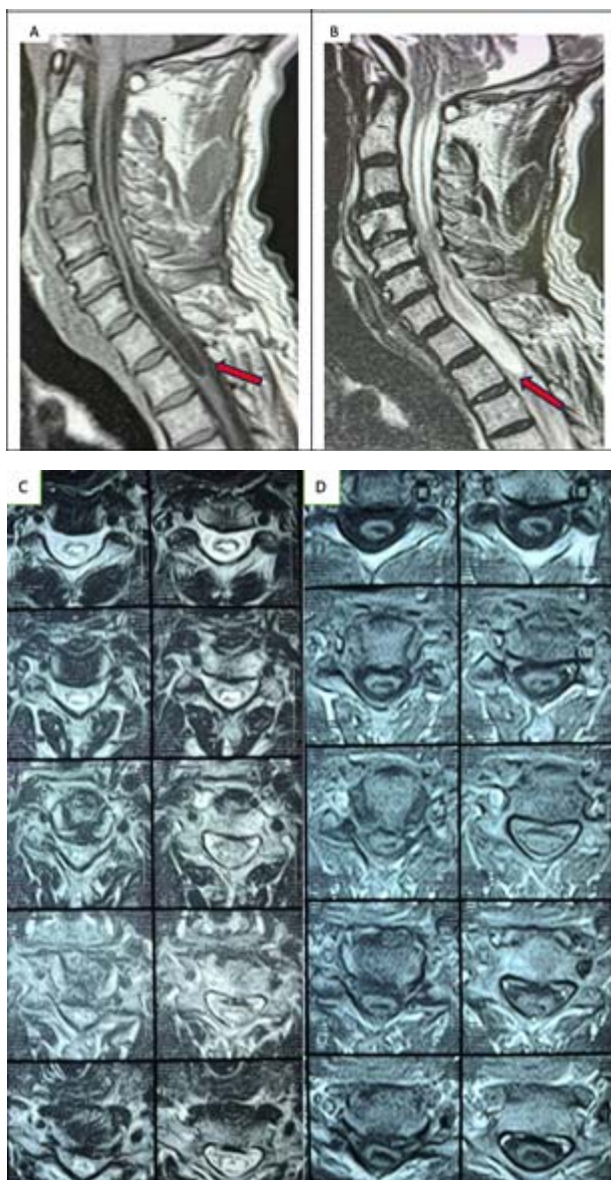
A) T1 and B) T2 sagittal MRI images demonstrating syringomyelia (red arrows), C) T1 and D) T2 axial MRI images.
